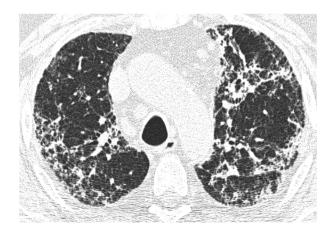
High-resolution computed tomography study showing the consequences of pulmonary toxicity caused by methotrexate. There is an irregular reticular pattern with areas of confluent opacities, small cystic changes and a few traction bronchiectasis. These abnormalities are predominantly located in the dorsal and basal part of both lungs. Although on this slice there is some extension of disease in the anterior part of the left lung.
